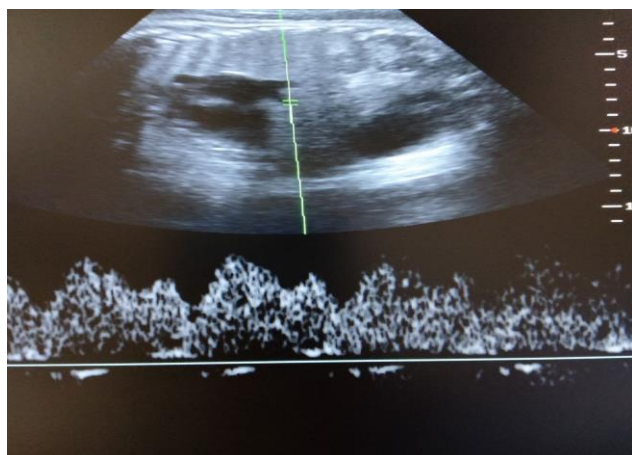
Ductus venosus Doppler in regular follow up.
